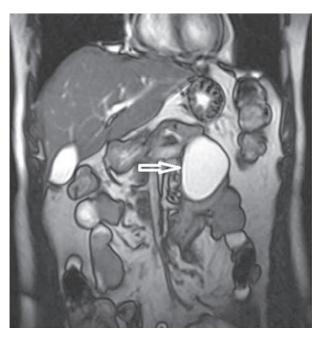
Cystic lymphangioma located at the junction of te tail and the body of the pancreas on magnetic resonance imaging; T2-weighed coronal section hyperintense.
